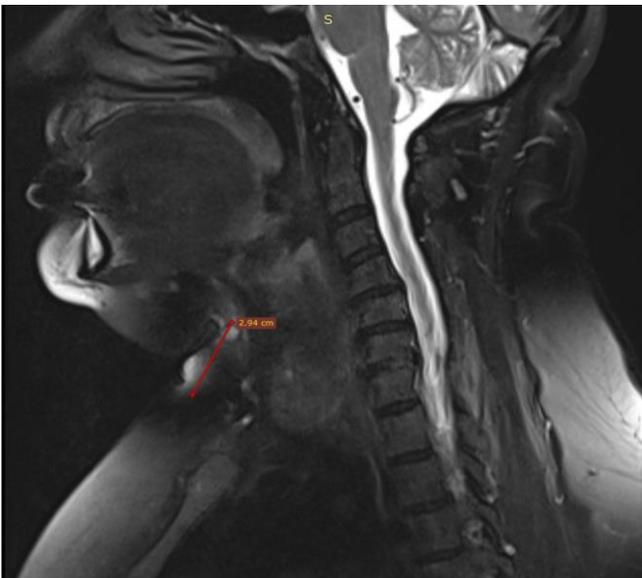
Magnetic resonance imaging of the thyroglossal cyst
